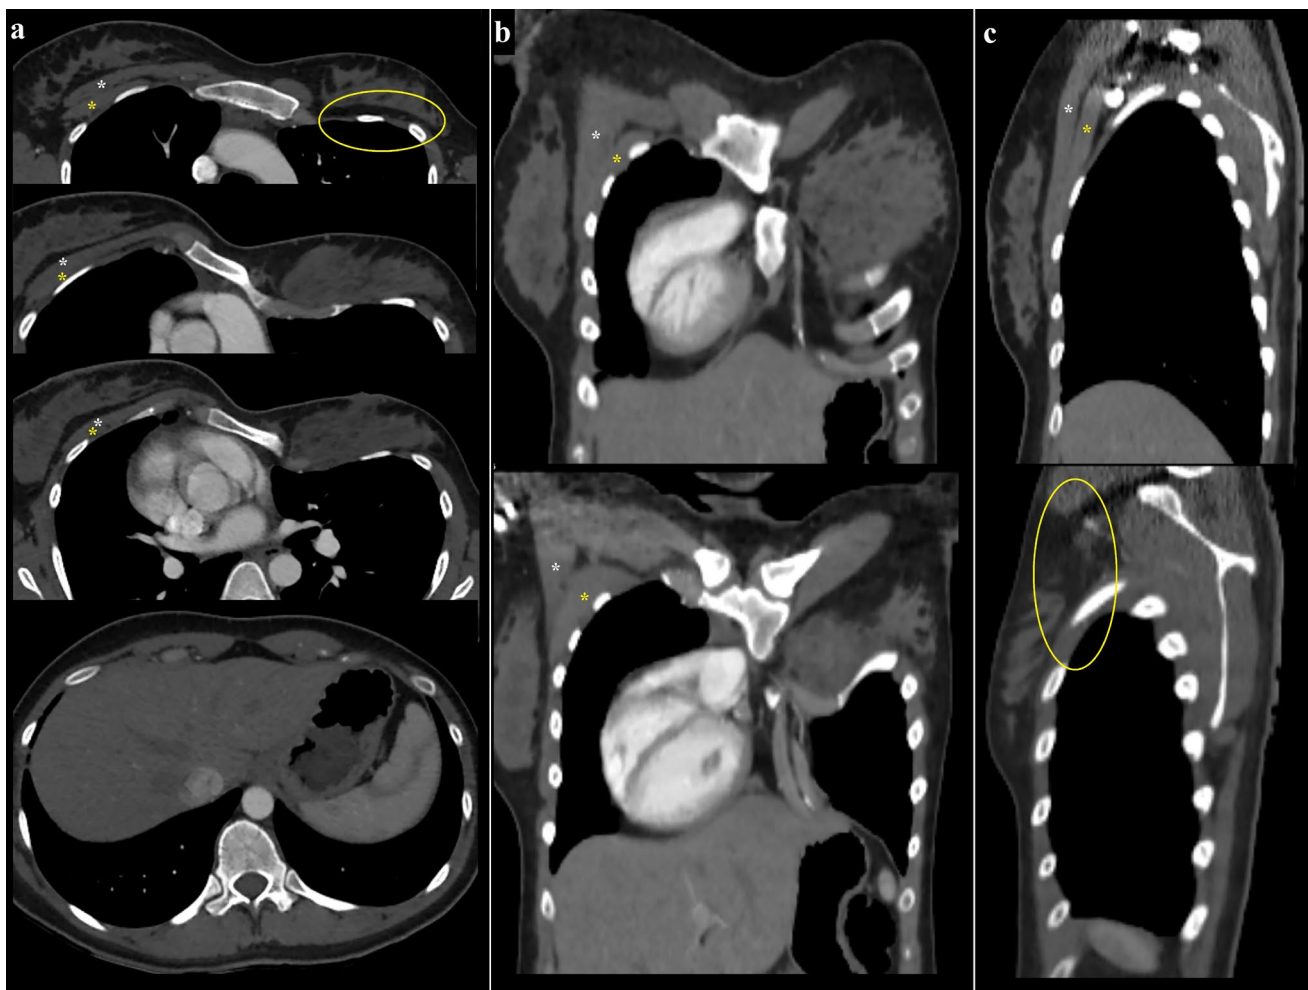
Chest computed tomography images obtained in axial (a), coronal (b) and sagittal (c) planes; It is noteworthy that the pectoral muscles are seen normally on the right side (white asterisk: pectoralis major; yellow asterisk: pectoralis minor) but the pectoralis major muscle is hypoplastic and the pectoralis minor muscle is agenesic on the left side. In addition, due to malformation in the sternum and left rib cartilages, pectus excavatum deformity and secondarily dextrocardia are observed.
